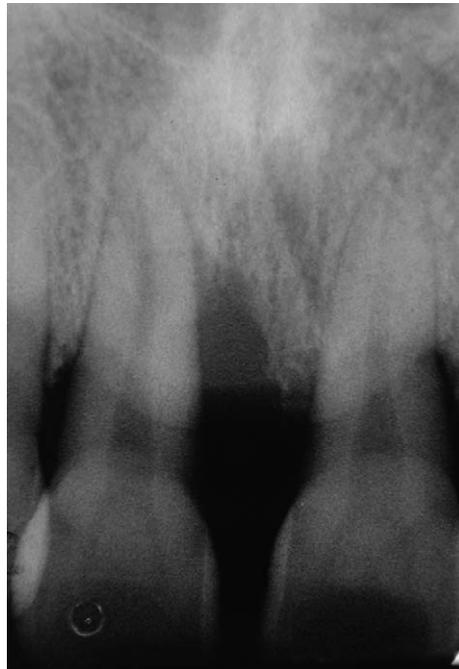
Preoperative radiography of the teeth.
